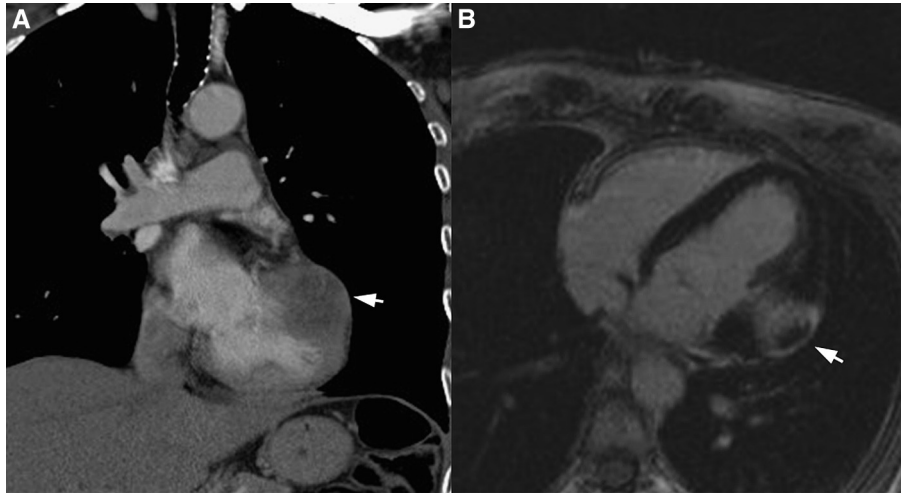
Cardiac metastasis. Axial contrast-enhanced computed tomography (A) and postcontrast volume interpolated breath-hold examination (VIBE) axial magnetic resonance image (B) of the chest in a patient with known primary adenocarcinoma of the lung and worsening shortness of breath, showing metastasis to the left ventricular free wall (arrows).
